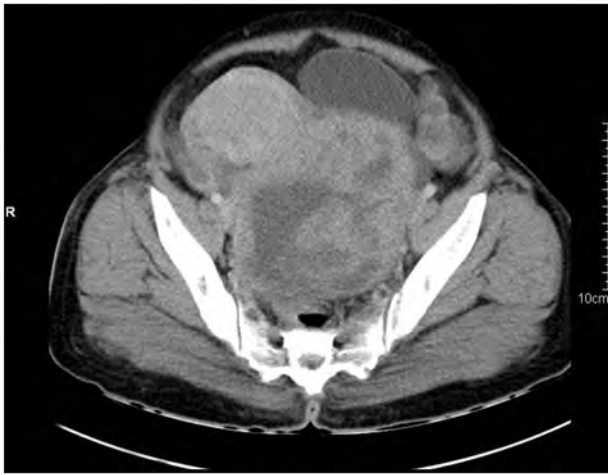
Contrast CT axial image showing heterogeneous enhancement of pelvic mass
